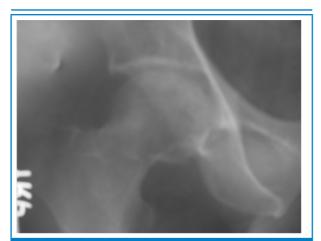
X-ray hips showing changes in femoral head with maintained joint space.
